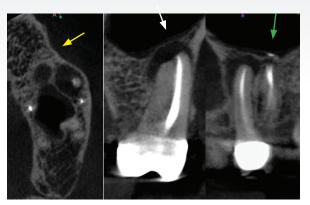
CBCT scan images showing that the apical pathology extending horizontally up to the sinus floor (white arrow), vertically in a mesial direction to the root of the maxillary second premolar (yellow arrow), and distally to the DB root of the tooth (green arrow)
